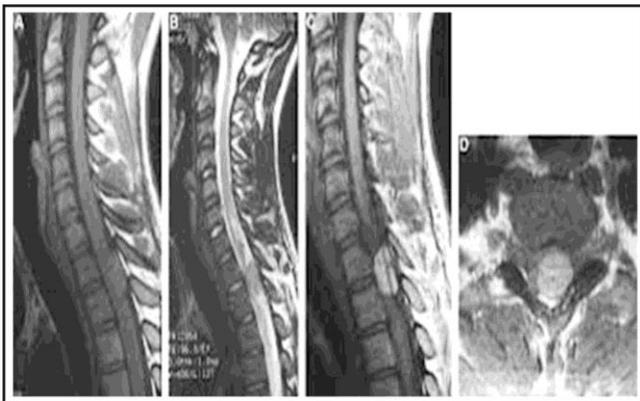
MRI cervicodorsal spine sagittal view T1, T2 weighted & contrast (A, B & C respectively) & axial view(D) showing meningioma at D1-2 level (Images included with the consent of the patient).
